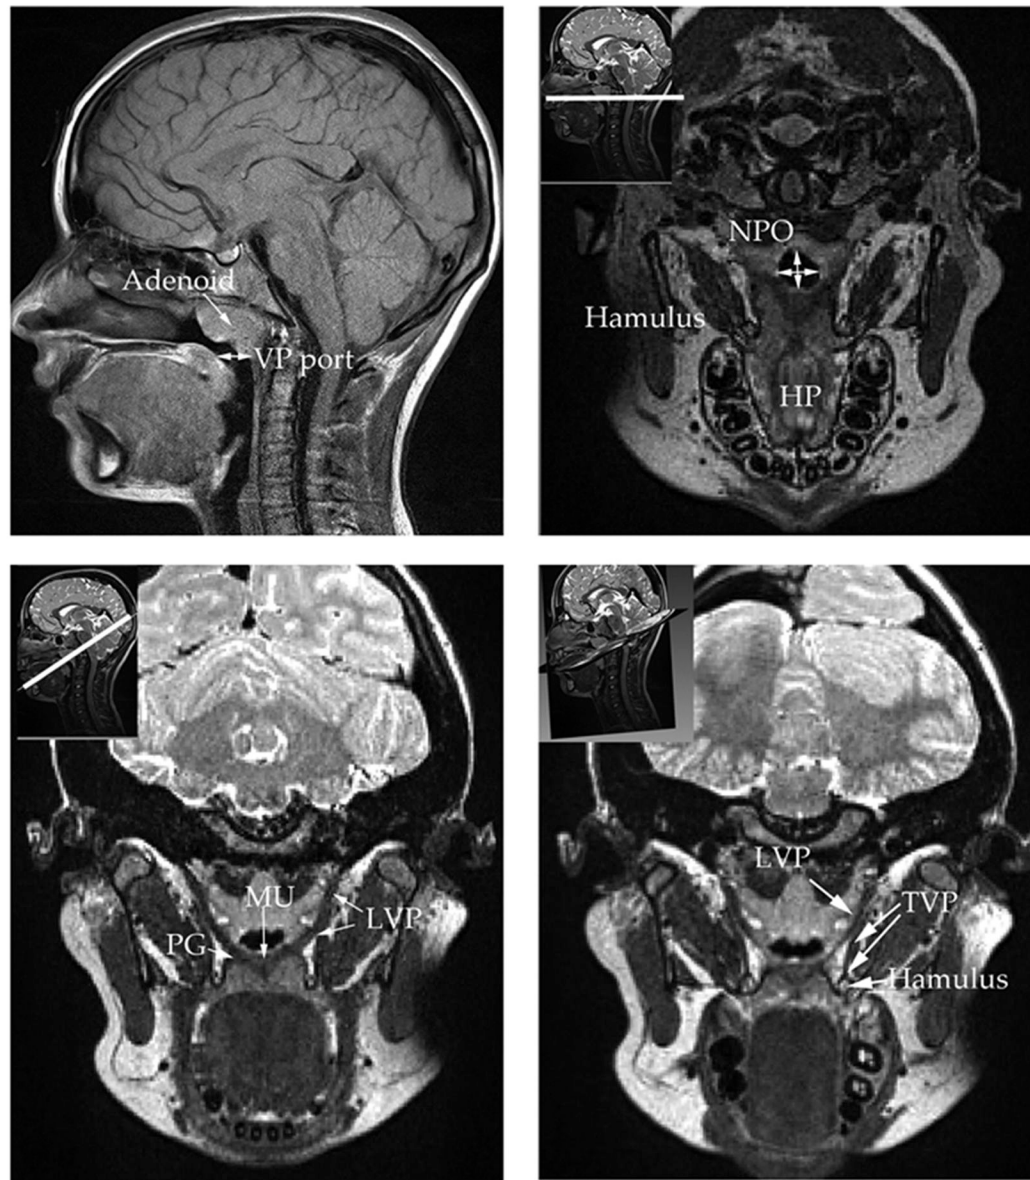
Demonstration of the multiple viewpoints achieved using MRI to demonstrate sagittal (top left), axial (top right), oblique coronal (lower left), and an angled oblique coronal (lower right). As evident velar, velopharyngeal port (VP port), nasopharyngeal opening (NPO), cranial structures, hamulus, adenoids, musculus uvulae (MU), levator muscle (LVP), and palatoglossus (PG) can be visualized.
